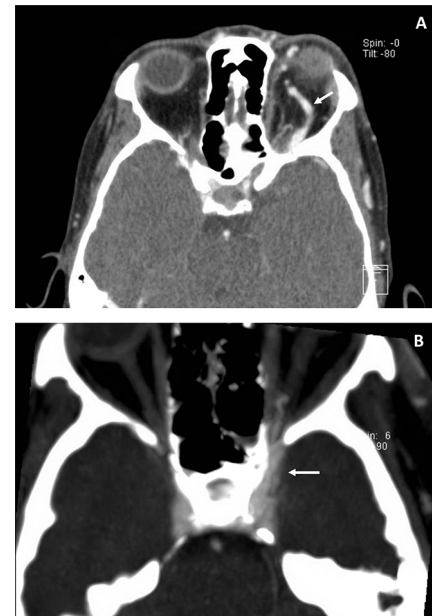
(A) CT scan demonstrating left orbital proptosis and enlargement of the left orbital vasculature (arrow). (B) CT angiography revealing an enlarged left cavernous sinus (arrow), mild enlargement of the left extraocular musculature, and engorgement of the left superior ophthalmic vein indicative of a carotid-cavernous fistula.
